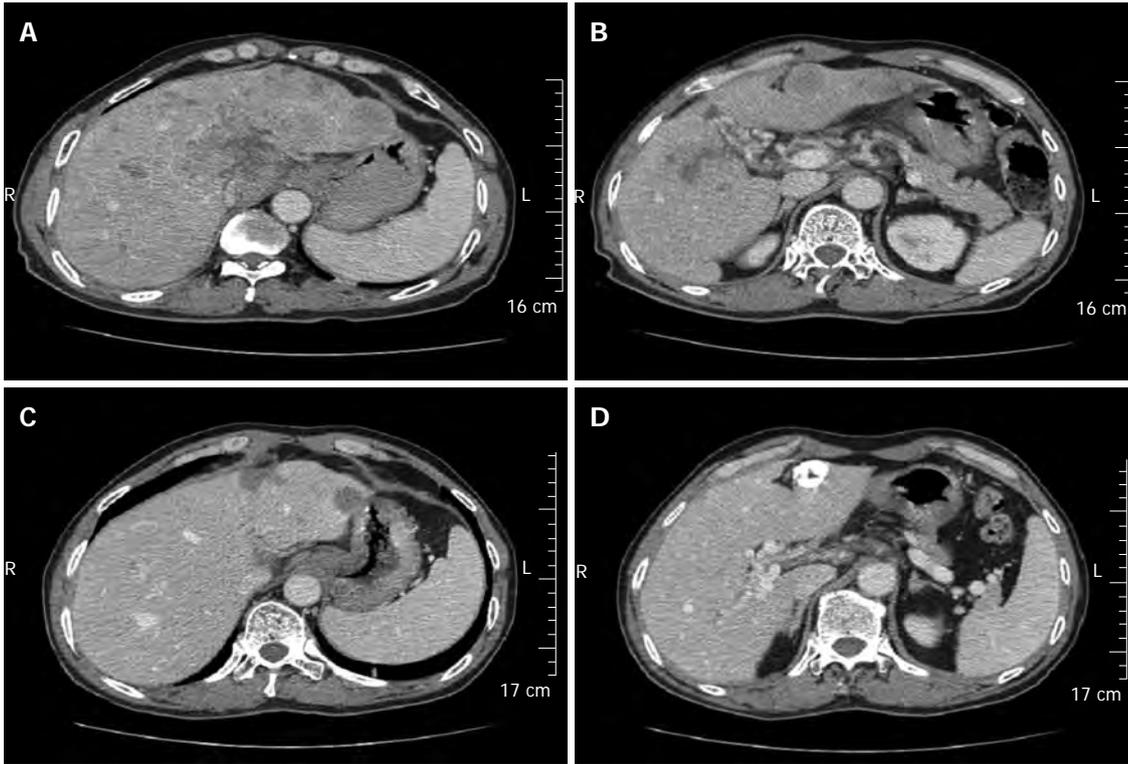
Computed tomography imaging of the gastric tumor and liver metastatic tumor. A and B: Computed tomography-scan revealing thickening of the wall of antrum, enlarged lymph nodes at the lesser curvature, multiple hepatic tumors in the bilateral lobes of the liver, tumor thrombus in the portal vein and its branches; C and D: After comprehensive therapies, enlarged lymph nodes had decreased in size and the liver metastatic foci were stable.
